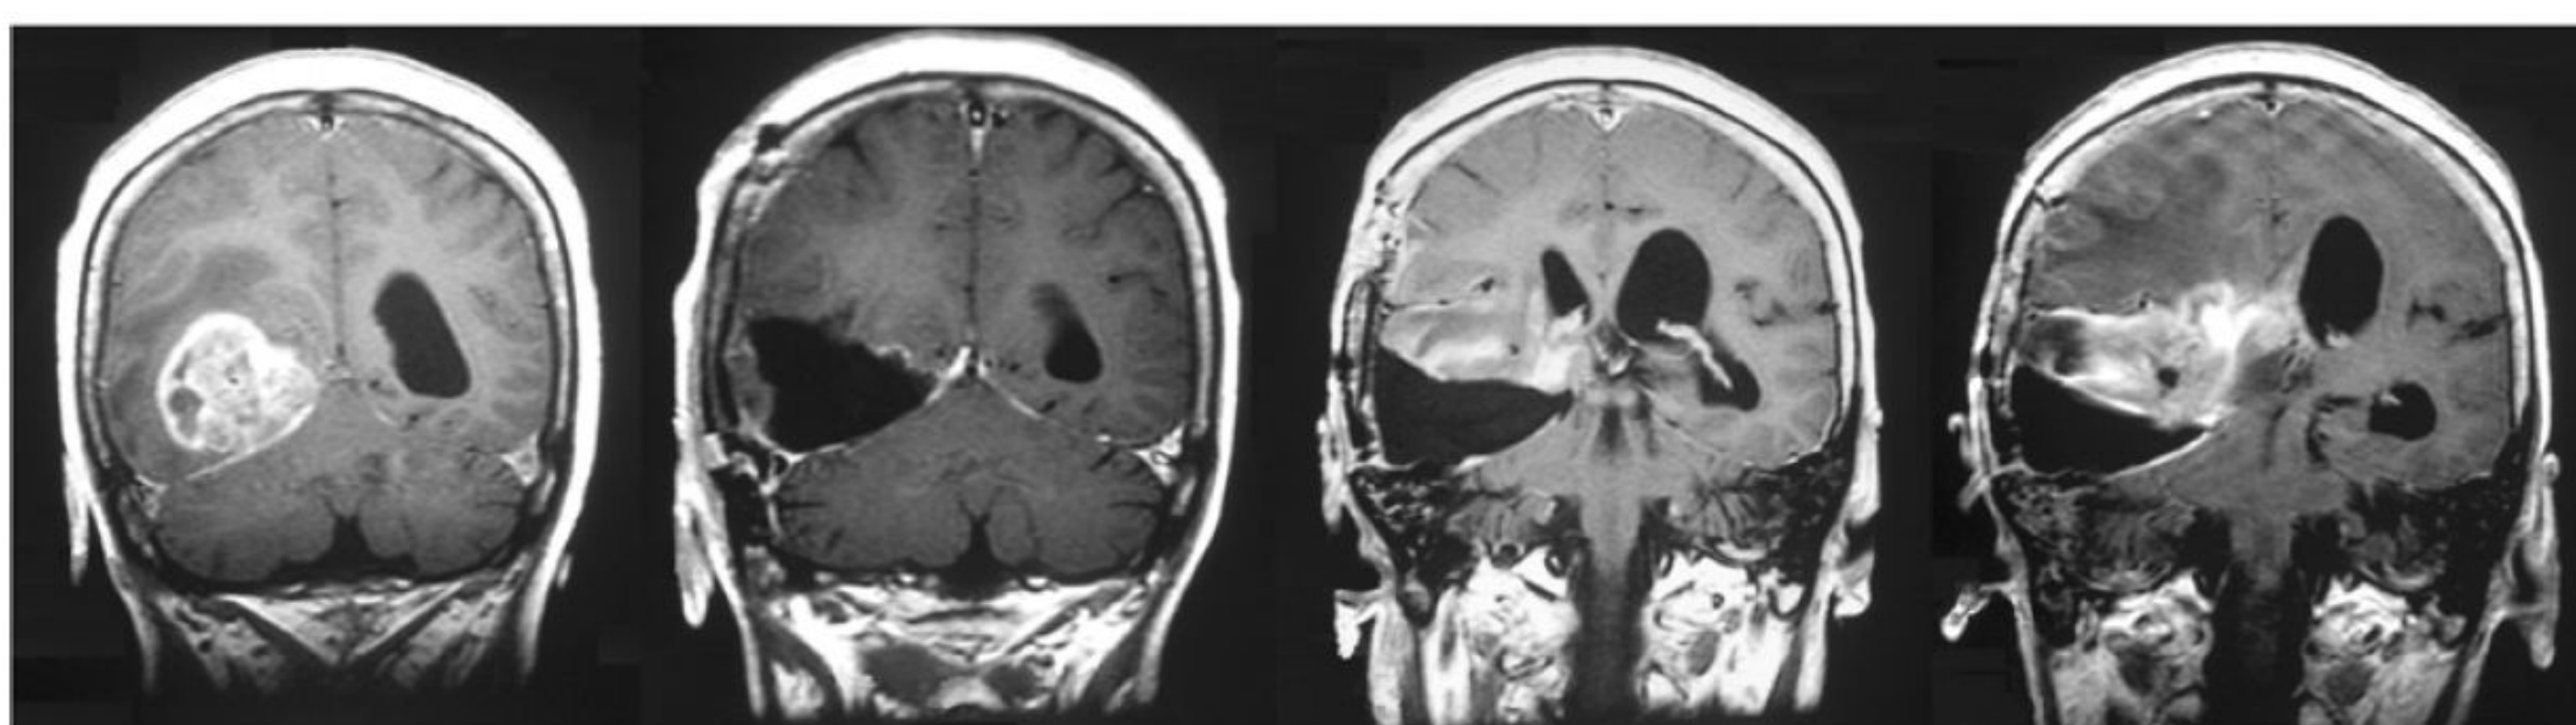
MRI scans of a glioblastoma patient who underwent surgical resection and chemotherapy treatment of GBM tumor in the right occipital lobe. 12 months after treatment, tumor recurrence was found in an MRI scan.⁴
